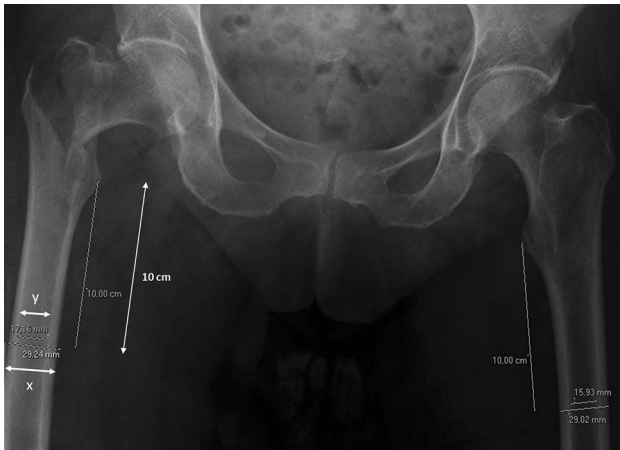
FCI is calculated using diameter of the shaft (x) and the internal diameter of medullar canal (y). FCI is obtained through the ratio between thickness of cortical bone ($x-y$) and diameter of femoral shaft (x) measured 10 cm distal to the center of the small trochanter in an AP view X-Ray of the pelvis, on fractured femur and on the opposite side
